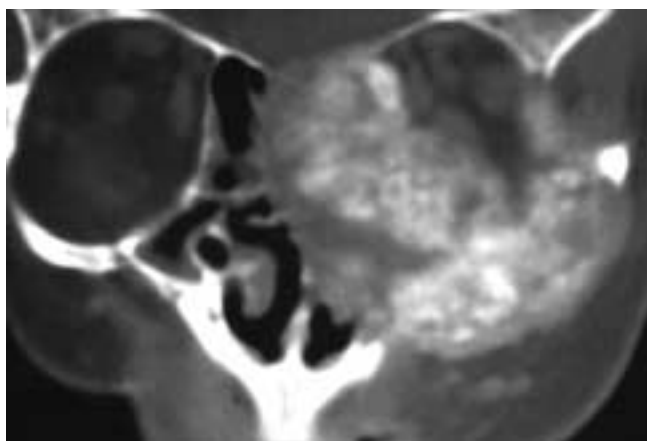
Coronal CT scan shows diffuse, irregular tumoral calcifications in the left face invading the ethmoid, anterior cranial fossa floor, nasal fossa, orbit, maxillary sinus, and cheek. This patient had metastatic sarcoma with calcium deposition.
